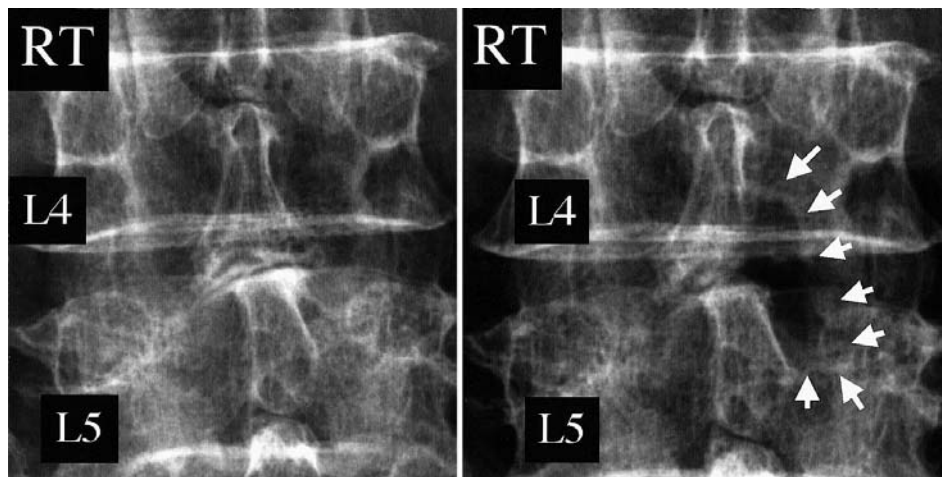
Case 5. Radiographs obtained before (*left*) and after operation (*right*). *White arrows* indicate the laminectomy-treated area.
